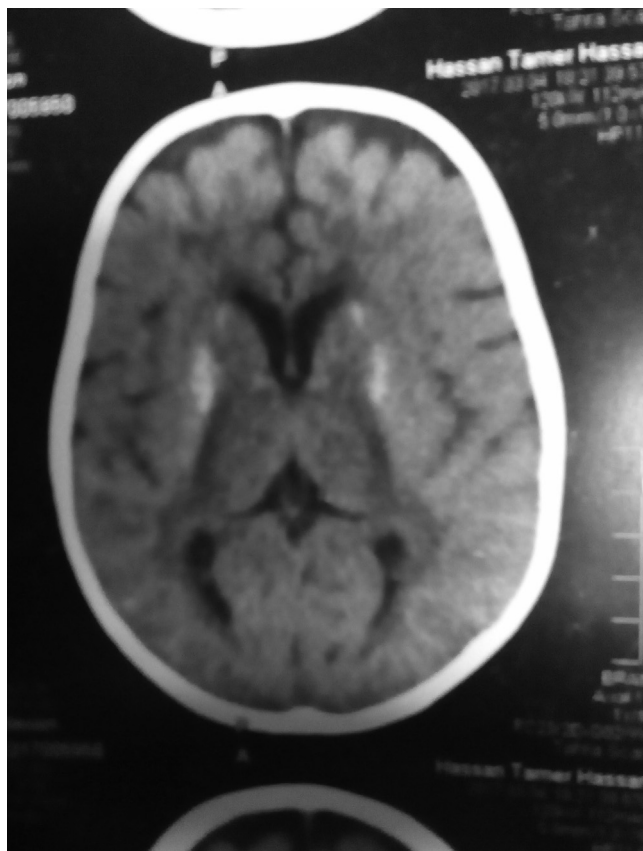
CT brain showed bilateral basal ganaglia and corona radiata calcifications.
